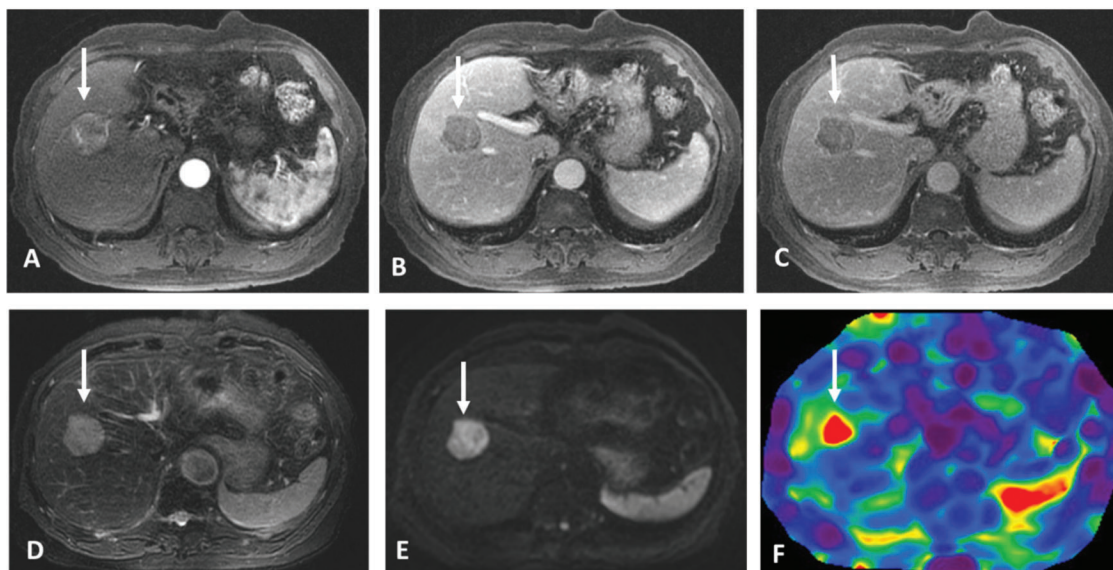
Axial magnetic resonance imaging of the abdomen of a 63-year-old patient with chronic hepatitis. (A) Demonstrates mosaic arterial phase hyper-enhancement with washout and pseudocapsule formation on portal venous phase (B) and delayed phase imaging (C). The mass demonstrates moderate signal intensity on T2-weighted image (D), moderate restricted diffusion (E) and increased stiffness on magnetic resonance elastography (F). The mean stiffness of the hepatocellular carcinoma was 8.2 kPa and the background hepatic stiffness of only 2.9 kPa suggestive of a non-cirrhotic liver parenchyma.
